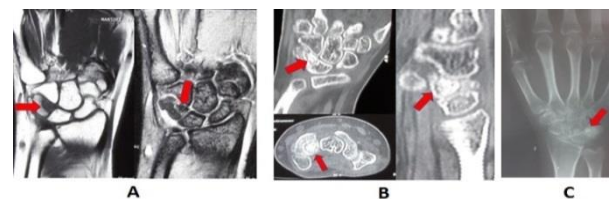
Preoperative images. A: Preoperative magnetic resonance imaging (MRI), showing triquetral lesion; B: Computed tomography (CT) scan showing the lesion at anterior-distal surface of triquetrum with central nidus; C: Immediate preoperative x-ray anteroposterior (AP) view, showing sclerotic lesion at triquetral pisiform junction
